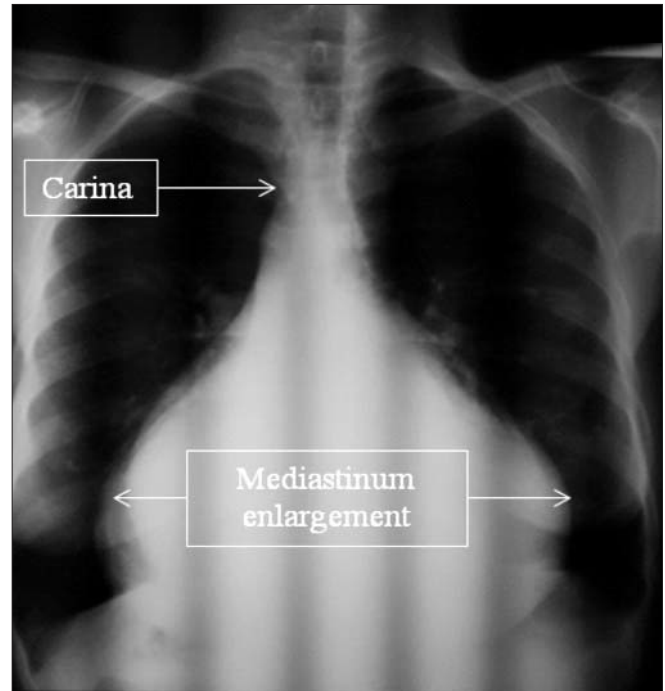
Thoracic X-ray – enlargement of mediastinal shadow
